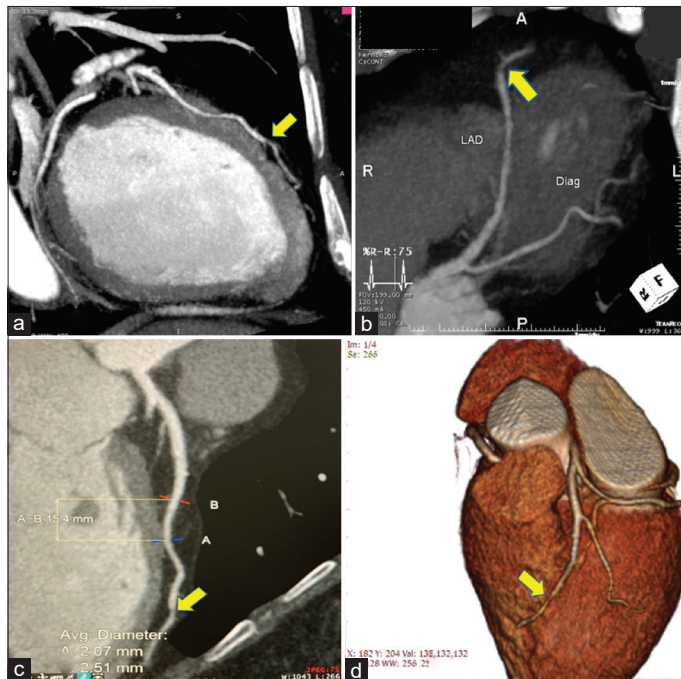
Evaluation of computed tomography (CT) angiography and volume rendering. (a-c) coronary CT angiography (CCTA) showed non-calcified plaque (yellow arrow) at the distal LAD with 50–60% stenosis. (d) CCTA with volume rendering showed similar stenosis at the distal of left anterior descending
